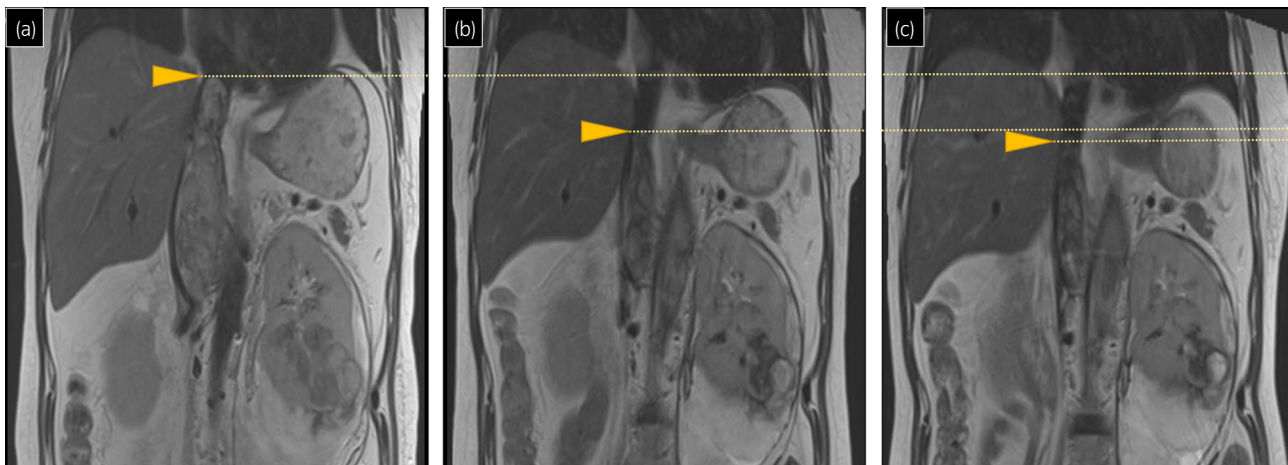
T2-weighted magnetic resonance imaging (MRI) showing downstaging of the vena cava thrombus. (a) Pre-treatment, (b) after two cycles, and (c) after four cycles of the combination therapy.
